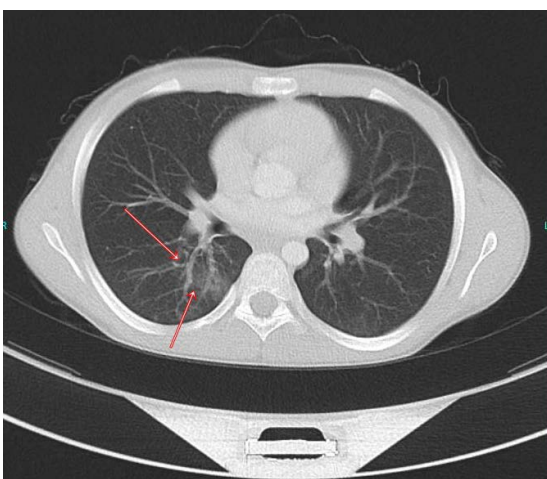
Axial view of HRCT image showing the presence of patchy, ground glass view and air trapping with no enlarged hilar lymph nodes and a normal mediastinal silhouette on superior segment superior and apical segment of the right lung. (red arrows).
